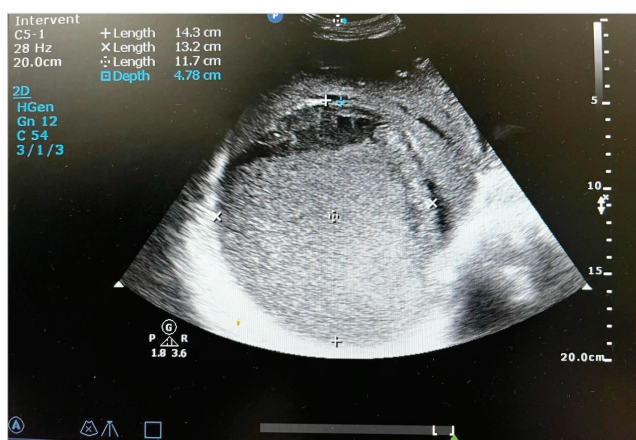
Ultrasound to assess the volume.
